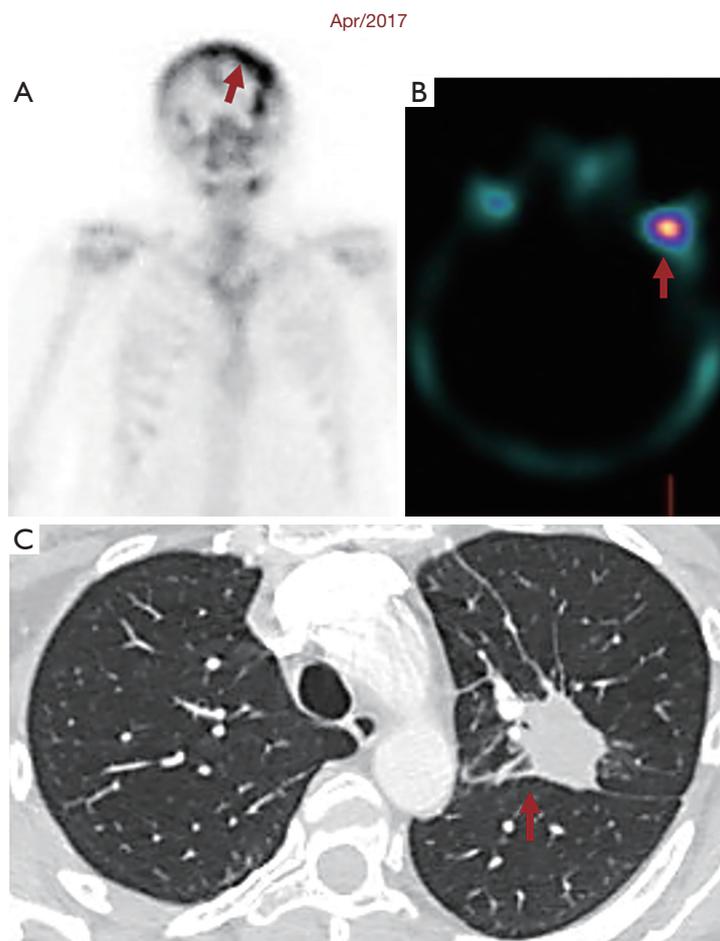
The tumor progressed in the skull, the lateral region of the left orbit and in the primary tumor. (A) Polyostotic metastatic disease in progression due to a lesion with a moderate osteogenic component in the skull. The arrow shows a lesion in the skull with a moderate osteogenic component. (B) CT combined with SPECT revealing changes for orbital metastasis. The arrow shows the orbital metastasis. (C) Thoracic CT scan shows the infiltrative left hilar mass causing medial atelectasis in the upper lobe. Also, tumor involvement in paratracheal and left hilar lymph nodes (the mediastinum window is not shown). The arrow shows the infiltrative left hilar mass causing medial atelectasis in the upper lobe and the tumor involvement in paratracheal and left hilar lymph nodes.
